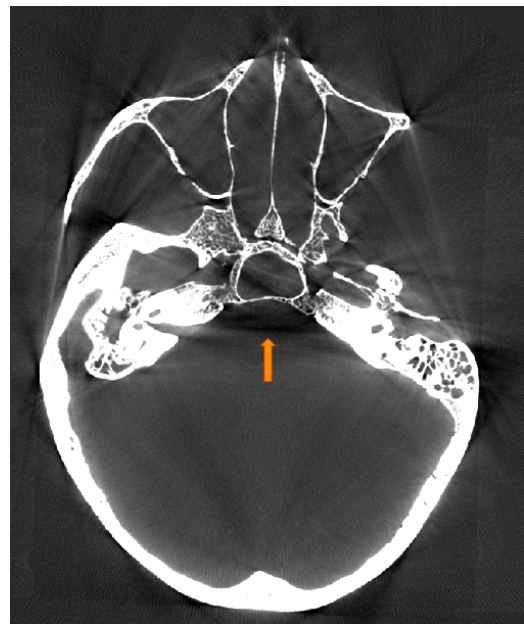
Example of beam hardening artifacts in CT images.
